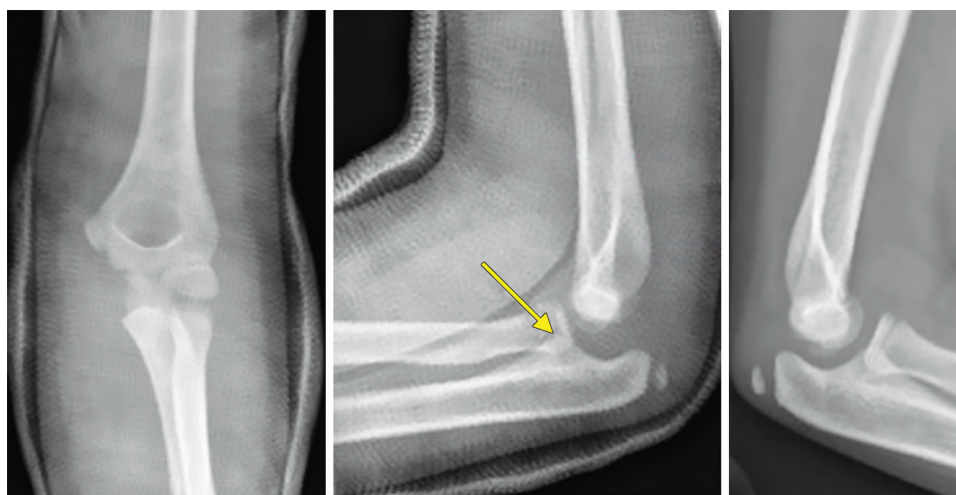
Postreduction radiographs demonstrating lack of concentricity of the injured elbow (left) relative to the contralateral side (right). The arrow highlights blunting of the coronoid process suggestive of a capsular avulsion fracture
